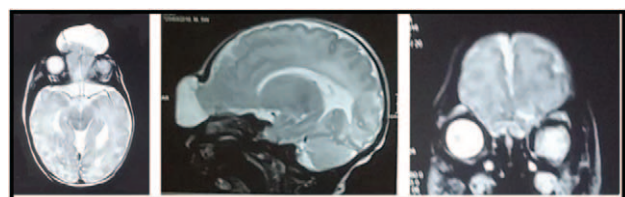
Preoperative MRI brain T2, axial, sagittal, and coronal cuts showing herniated dural sac with brain tissue.
